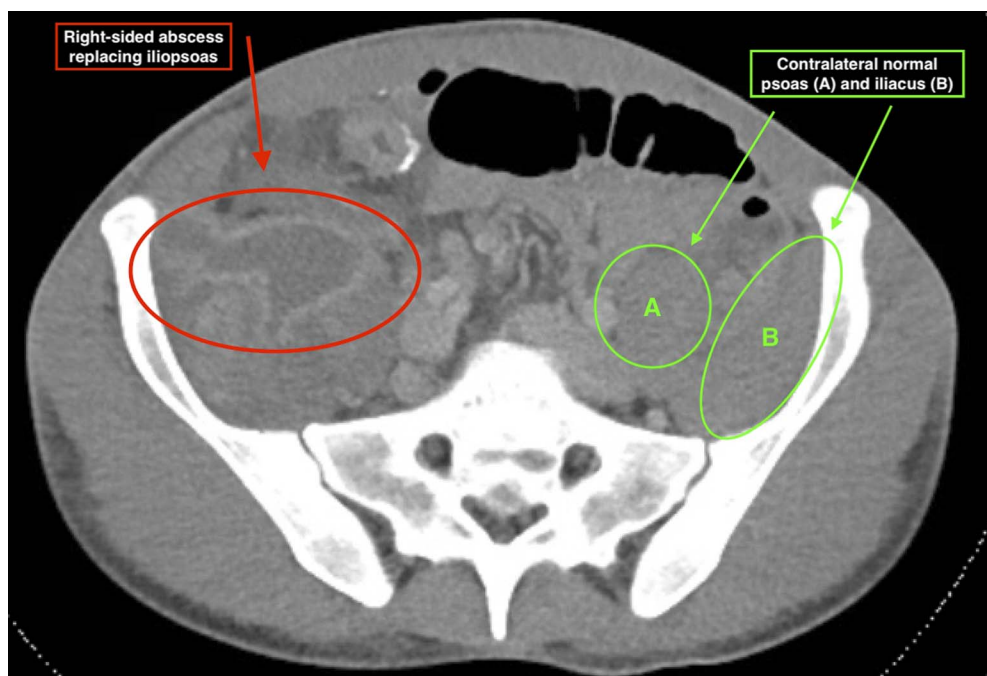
T2-weighted MRI revealing right-sided abscess replacing the iliopsoas and iliacus with corresponding normal contralateral anatomy.
